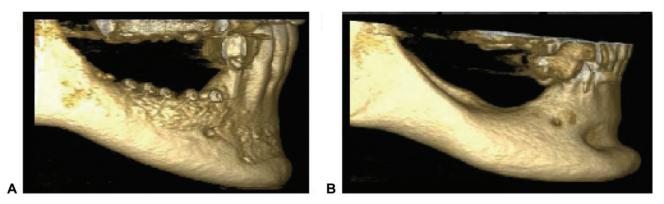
Representative postharvesting three-dimensional CT images: (A) healed filled symphysis donor defect and (B) healed unfilled symphysis donor defect.
